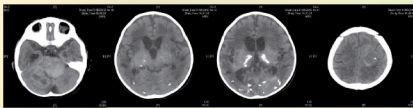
CT. Bilateral cortical and thalamic calcifications.
